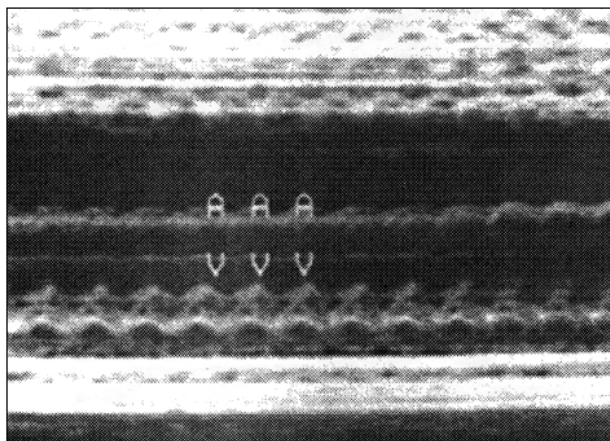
M-mode fetal echocardiogram showing atrial flutter with 1:1 atrioventricular conduction (heart rate >300bpm). A- atrial systole; V- ventricular systole.
